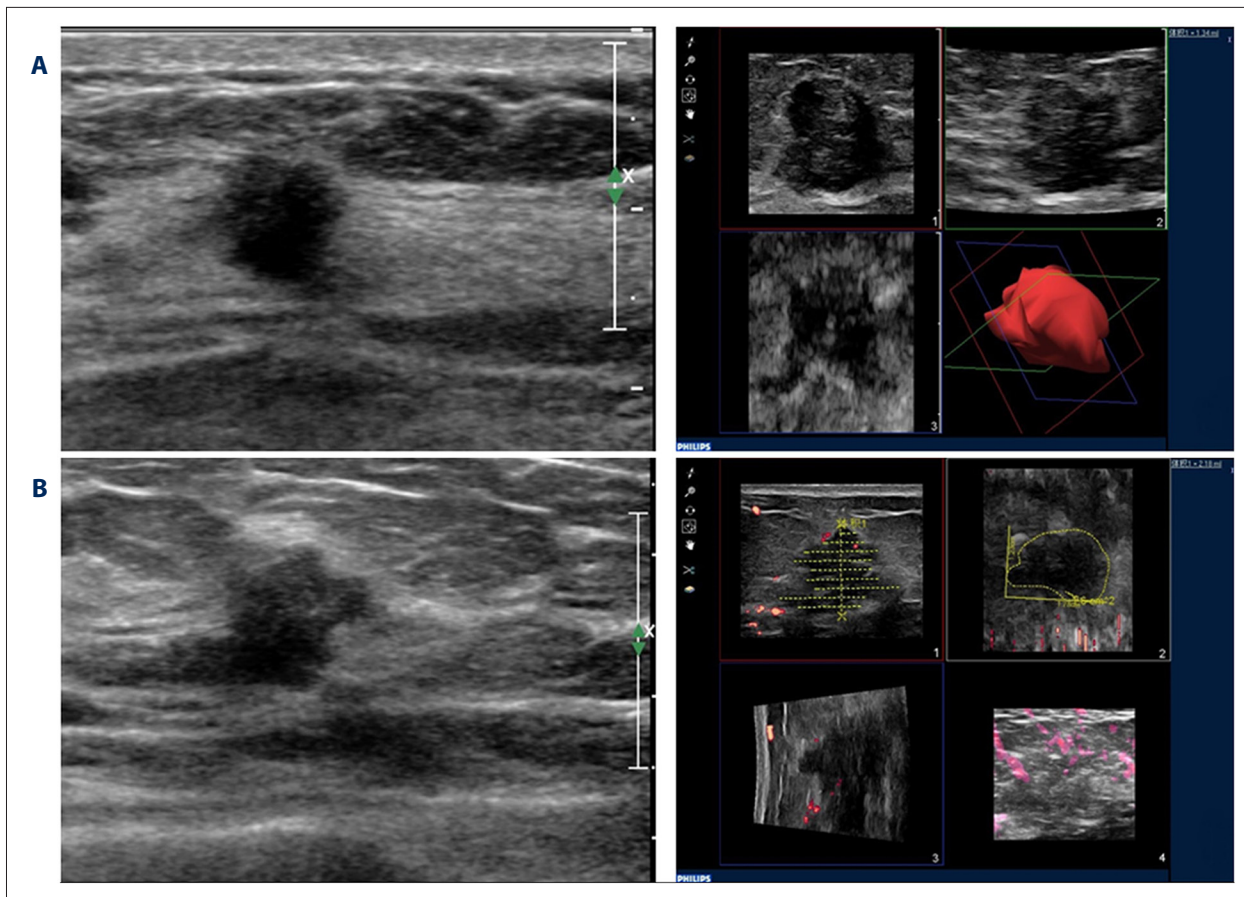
(A) Triple-negative type breast cancer patient with TVDT of 133 days. (A) First examination, volume=1.34 ml. (B) Second examination after 93 days, volume=2.18 ml. Left, primary ultrasound image. Right, TVDT calculation module.
